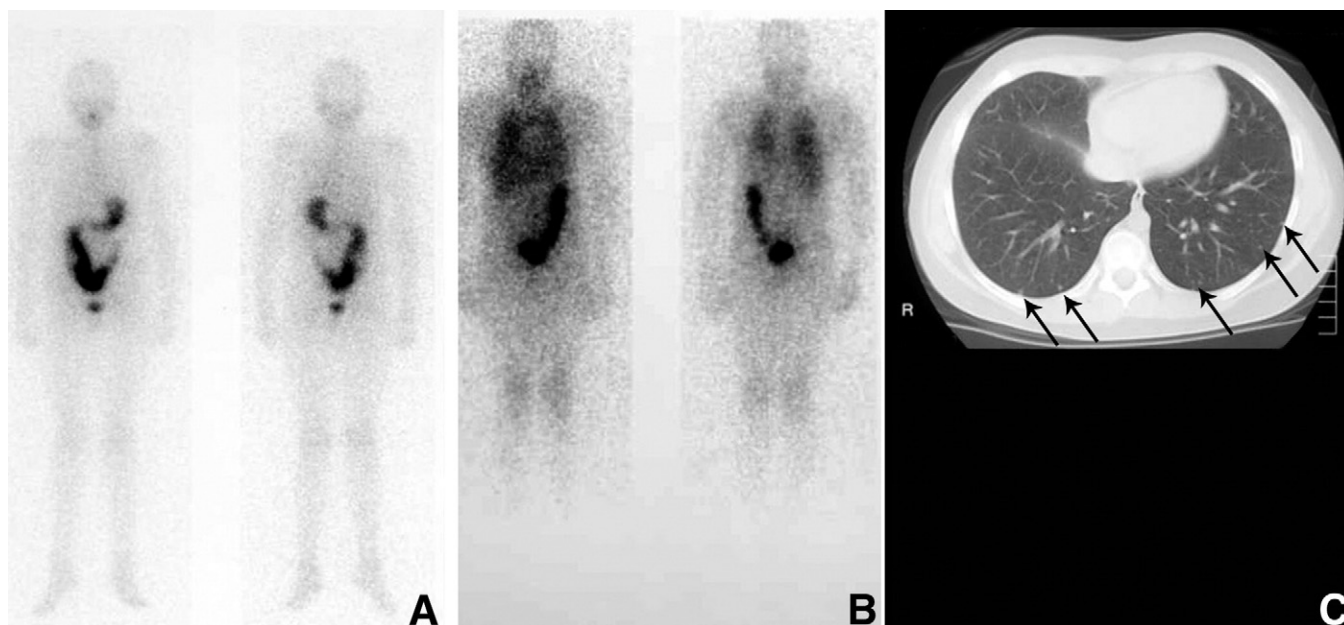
An 11-year-old s/p total thyroidectomy and lymph node dissection for papillary thyroid carcinoma with metastatic nodal involvement. (B) Anterior and posterior whole body images obtained 7 days after oral I-131 therapy clearly show diffuse lung metastases confirmed on noncontrast CT (C, arrows) but not seen on diagnostic (staging) postthyroidectomy I-131 scan (A). Dose related sensitivity of I-131 for detection of metastatic thyroid disease as seen in this case is well documented in the literature. Post-therapy I-131 whole body imaging at 7 to 10 days is mandatory in all patients as this may detect new or unexpected lesions in as many as 46% of patients.
